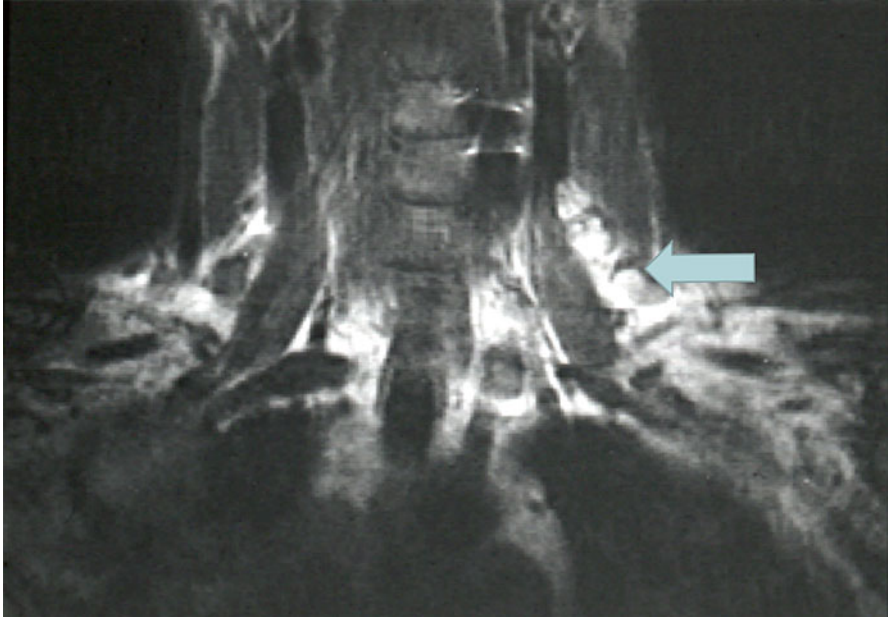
Magnetic resonance imaging (MRI) of patient's neck demonstrating lymph node metastases in left neck (*arrow*)
